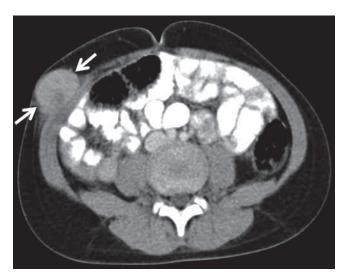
Two months after operation post contrast axial CT scan demonstrates a solid lesion in the right abdominal lateral wall (arrows).
